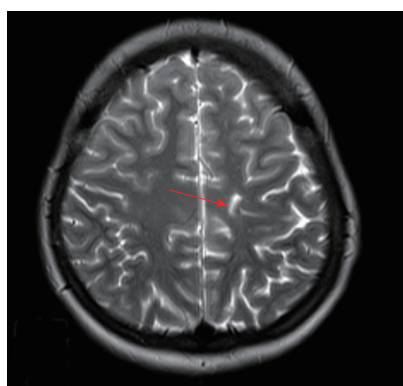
There was only a T2-weighted linear signal intensity with magnetic resonance imaging obtained after nine months.
